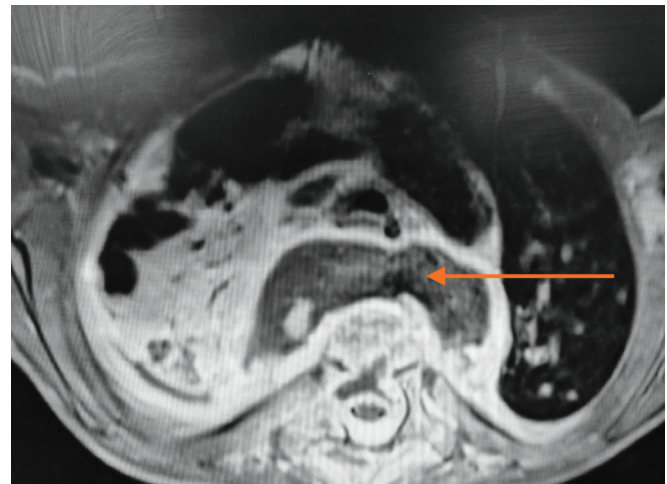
MRI T1 weighted image (axial view) showing epidural abscess
